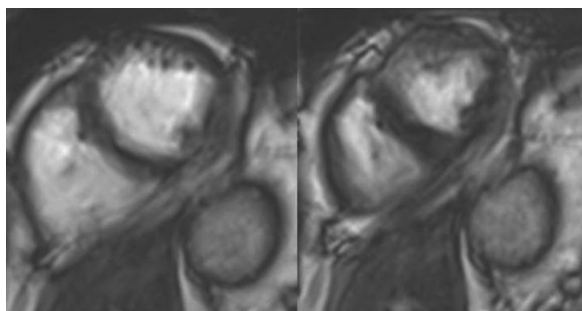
Cardiac MRI images with motion artifacts due to irregular intervals owing to arrhythmias. Images from [14].
